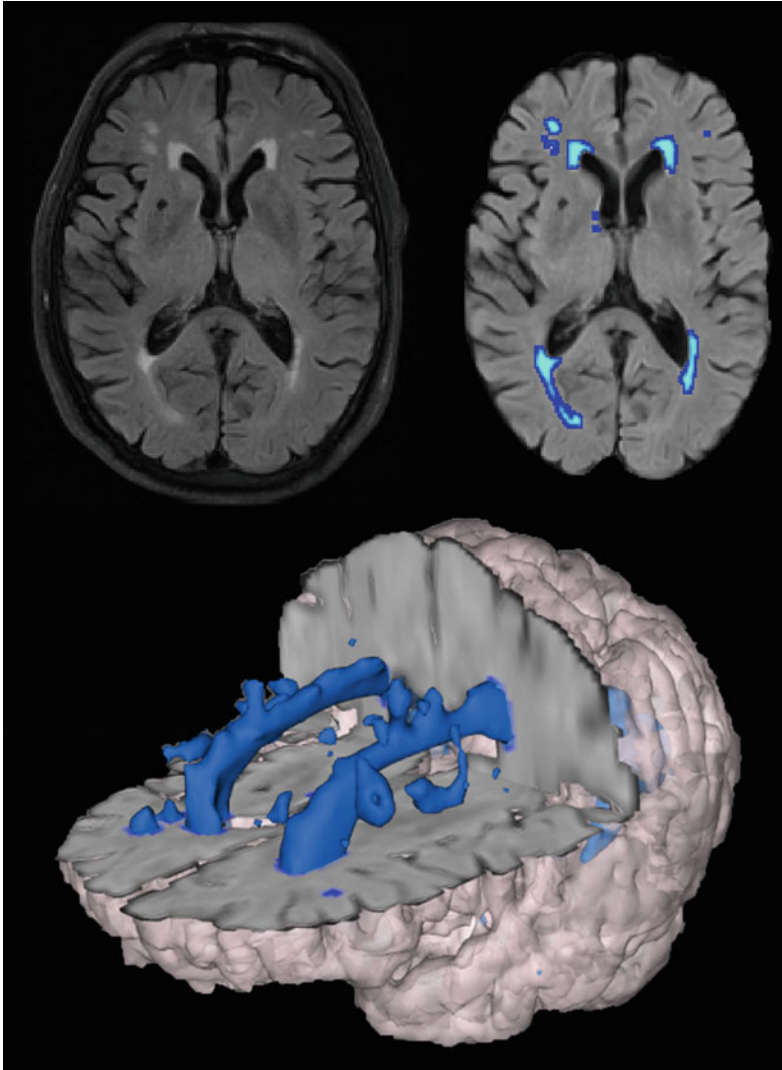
Quantitative volumetric assessment (segmentation) of WMH from FLAIR MRI (top left panel) highlighted in blue in axial plane (top right panel) and in a 3D rendering (bottom panel)
